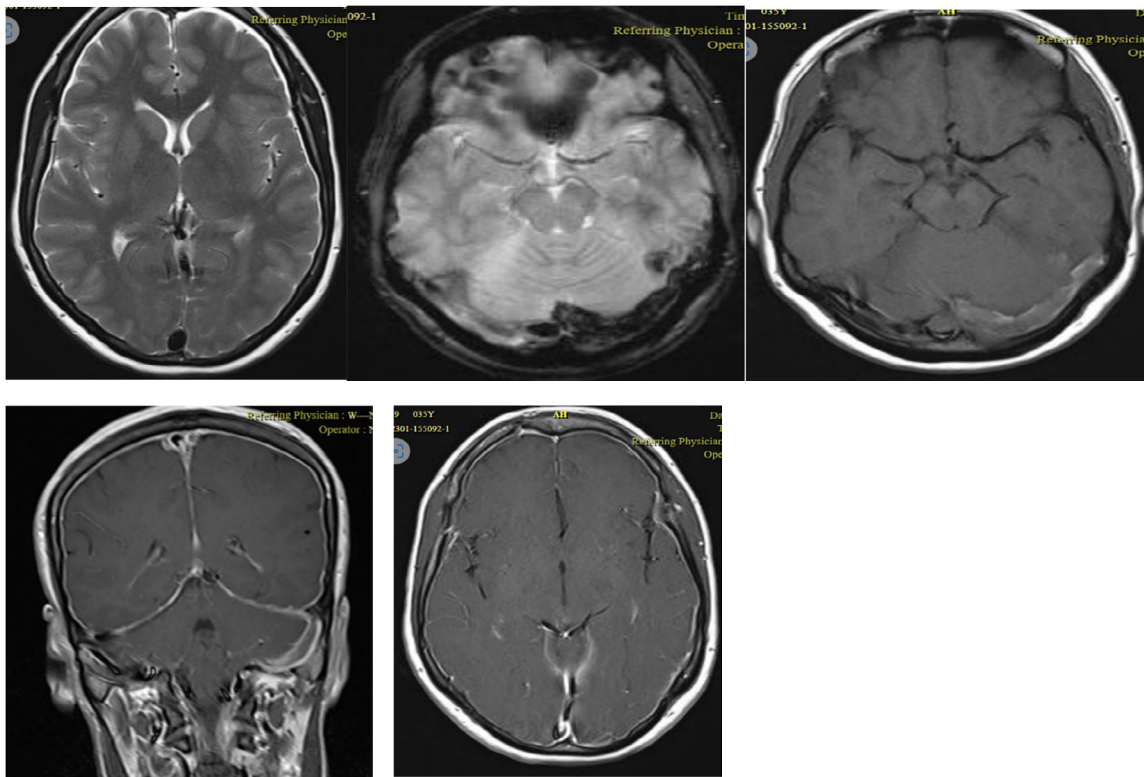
MRI sequences show an abnormal signal void in the T2 sequence, a blooming artifact in the GRE sequence, hyperintensity in the T1 sequence, and pachymeningeal enhancement in the post-contrast sequences.
